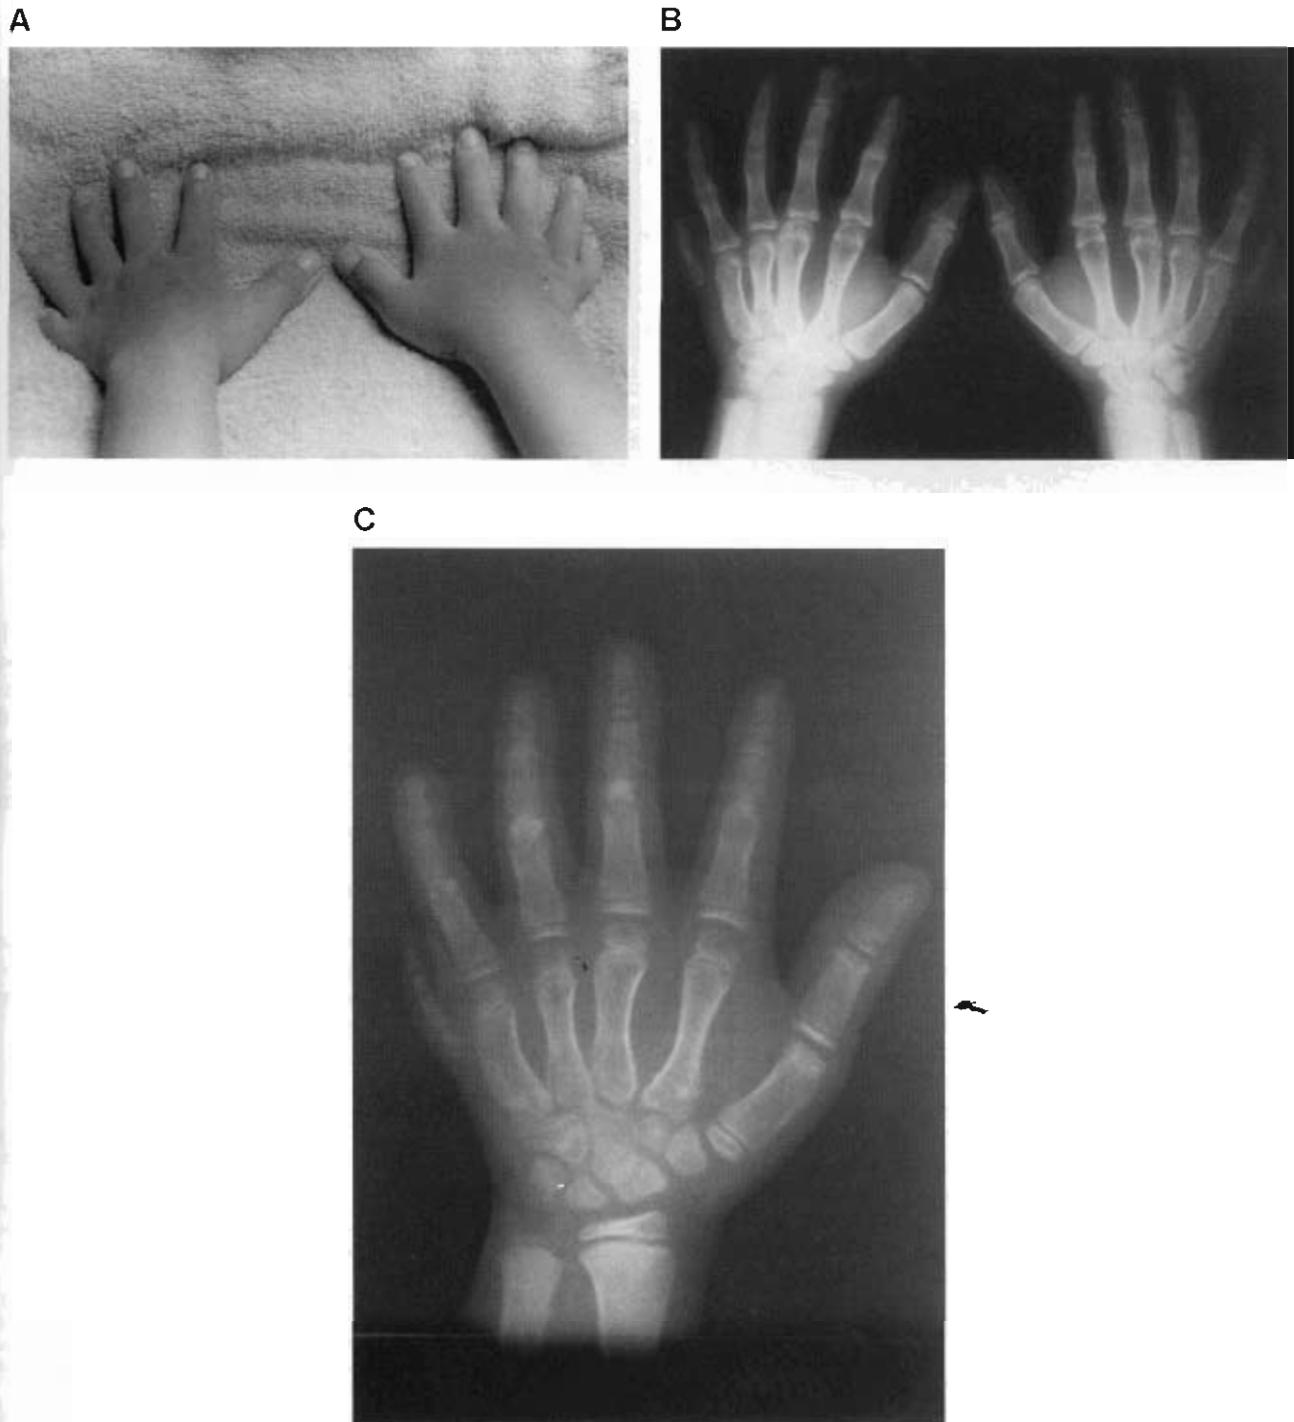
A: Postaxial polydactyly of hands. B: PA radiograph of hands at the age of 12 years. Note proximal and distal symphalangism. C: PA radiograph at the age of 7 years. Short middle phalanges of all fingers. All IPJ spaces are visible except for that of the proximal IPJ of the polydactylous one.
